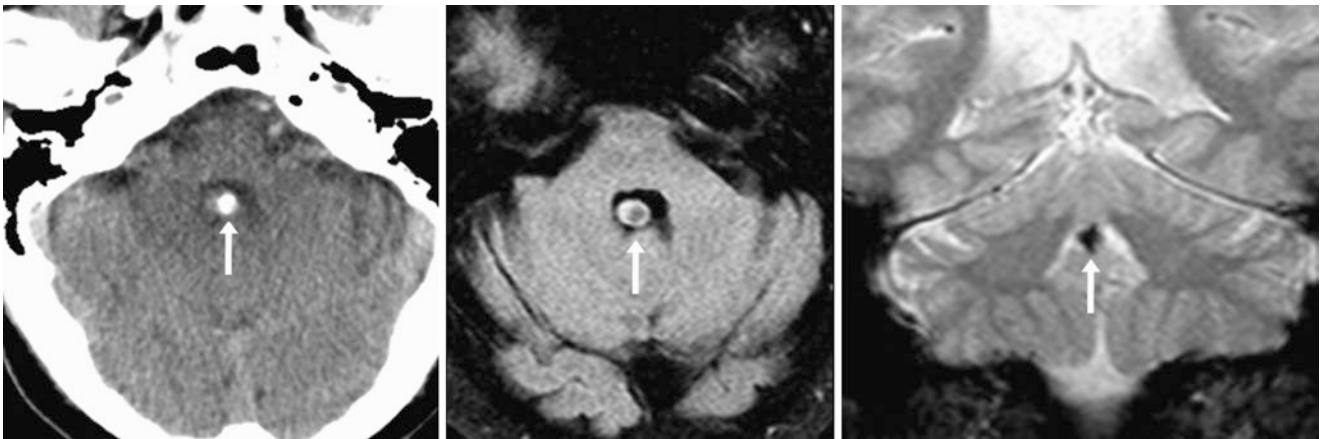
A 36-year-old patient with calcified CP (arrow) within the fourth ventricle along the cerebellar nodulus on axial NECT (left). On a 1.5 T MRI, the CP produced focal susceptibility artifact on axial FLAIR
